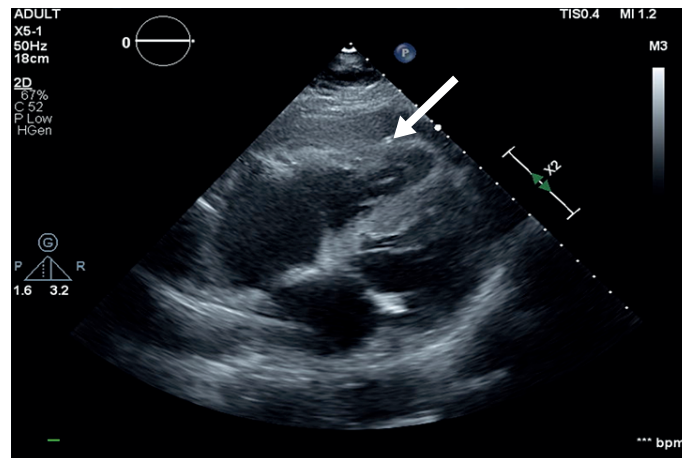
Transthoracic echocardiogram after transvenous pacemaker removal. Subcostal view showing improvement of pericardial effusion after pericardial drain placement (white arrow) with re-expansion of right ventricle.
